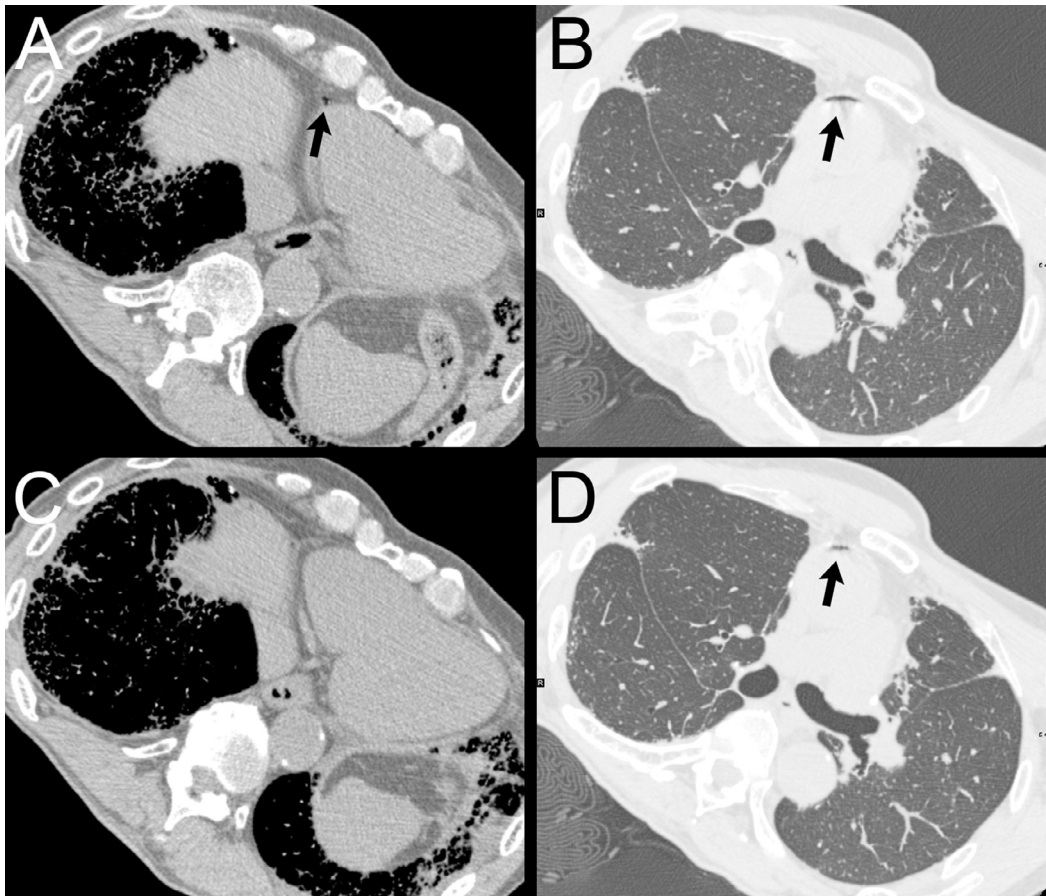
Chest Computed tomography (CT) scan immediately after biopsy. Immediately after the lung biopsy, CT images revealed air in the right coronary artery (A, arrow) and at the apex of the ascending aorta (B, arrow). Within 5 minutes, the air in the right coronary artery had dissipated (C), whereas air at the apex of the ascending aorta persisted (D, arrow).
